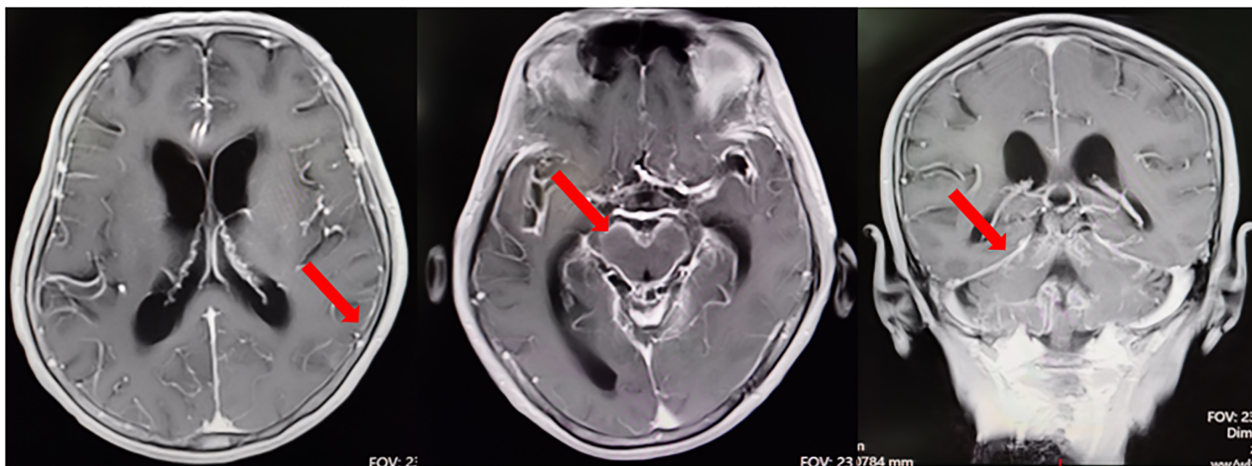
A representative case with typical images of brain MRI from patient 10 with leptomeningeal metastasis (LM). There were multiple abnormal signals in the occipital lobe, cerebellar hemisphere, and brainstem (red arrow). Multiple leptomeningeal metastasis was considered.
